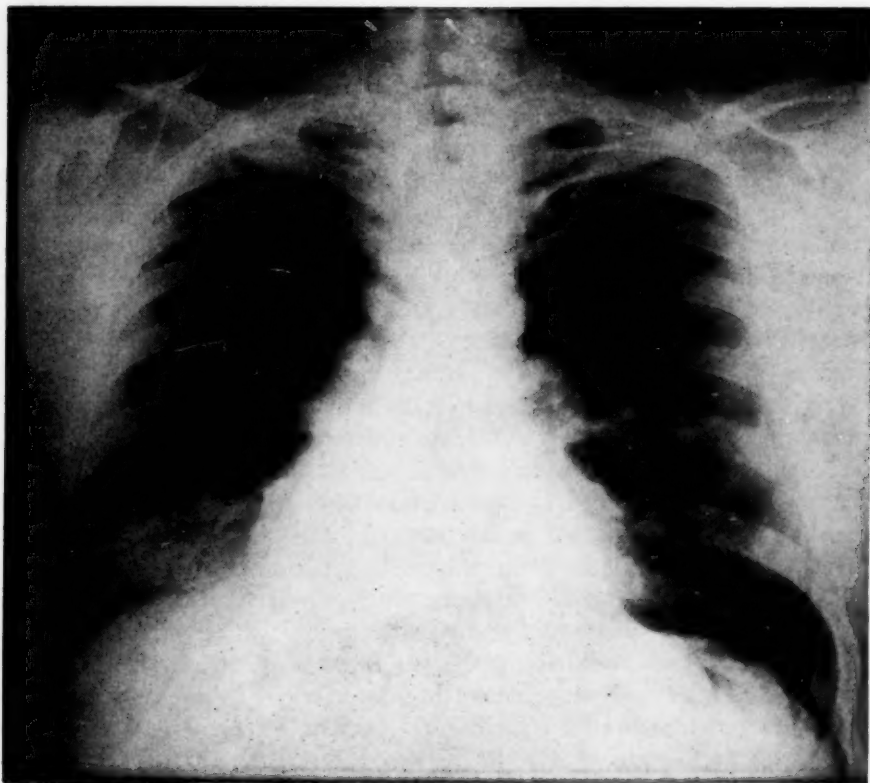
Chest roentgenogram of S. C. U. taken May 28, 1941, showing partial atelectasis of right lower lobe. Bronchoscopic biopsy showed squamous cell carcinoma.
